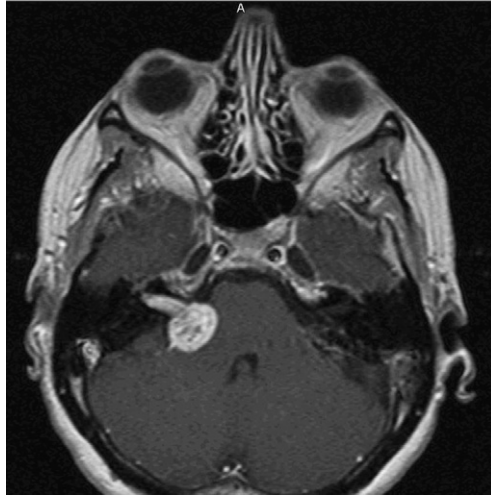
Axial MRI of large VS with brainstem compression.
